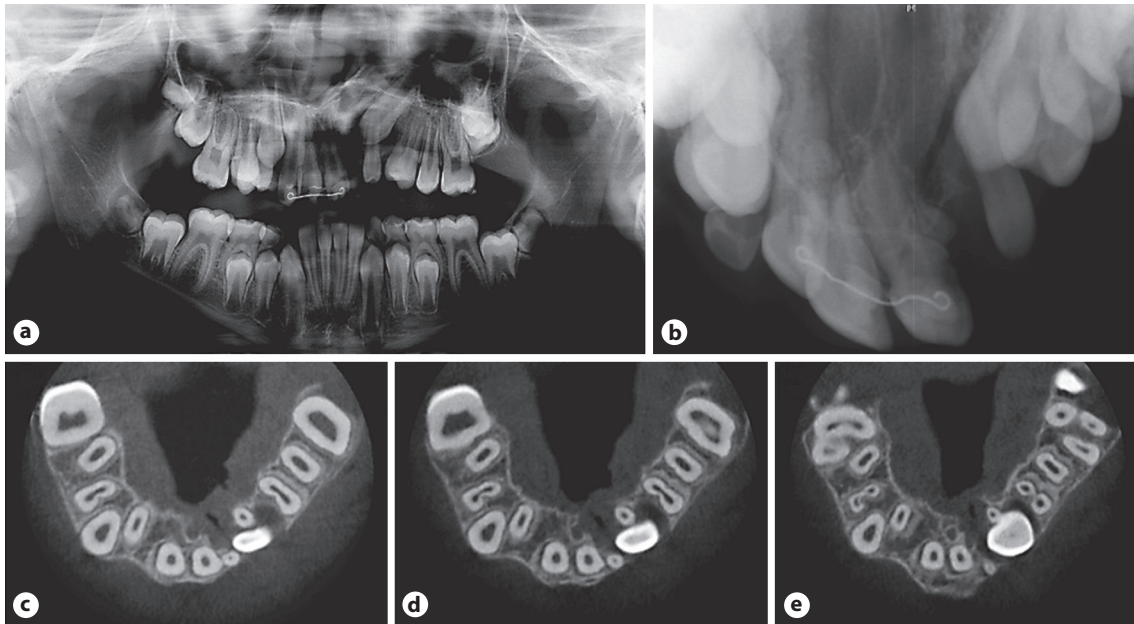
Panoramic (a) and upper standard occlusal (b) radiographs of a child with a complete unilateral cleft lip and palate demonstrating a late developing, unerupted supernumerary tooth adjacent to the UL1, transposition of the UL23 and potential molar stacking in the left maxilla. Cone-beam CT images (c–e) confirm the supernumerary's position and the degree of transposition, as well as the size and dimension of the cleft alveolus.
